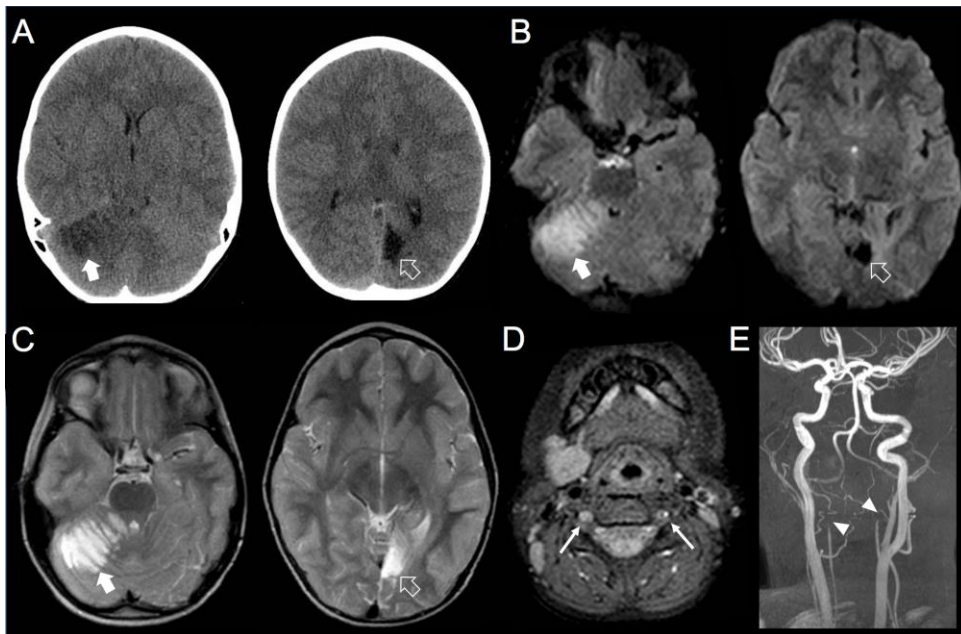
Neuroimaging of patient #20. Brain CT, MRI and MRA with multiple bilateral asynchronous AIS in the left PCA and right PICA arteries, due to multiple asynchronous VA dissections
